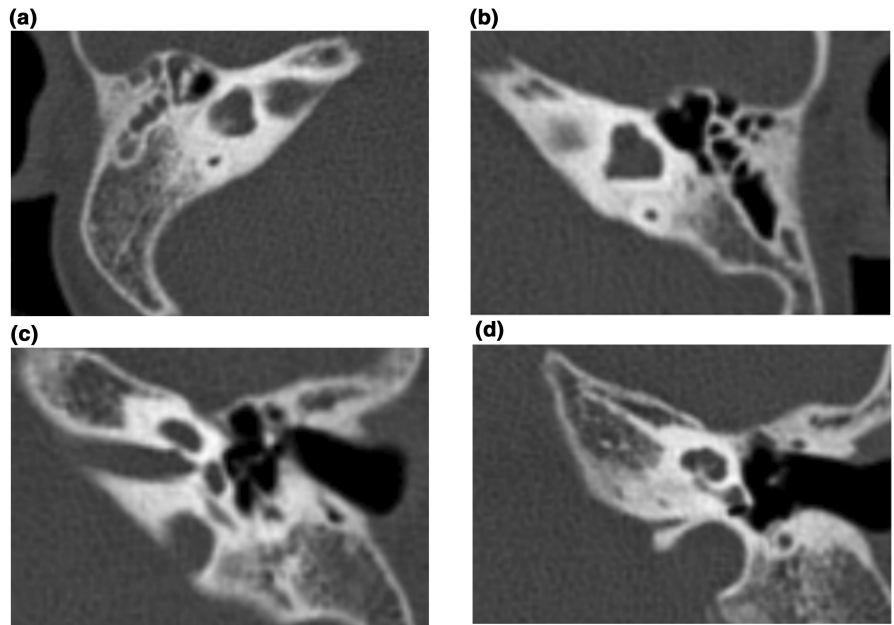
Axial images of HRCT of patient 2: (a) Right ear: irregular morphology of the long feet of the incus; bone hardening of the oval windows. (b) Left ear: irregular morphology of the long feet of the incus; bone hardening of the oval windows.
